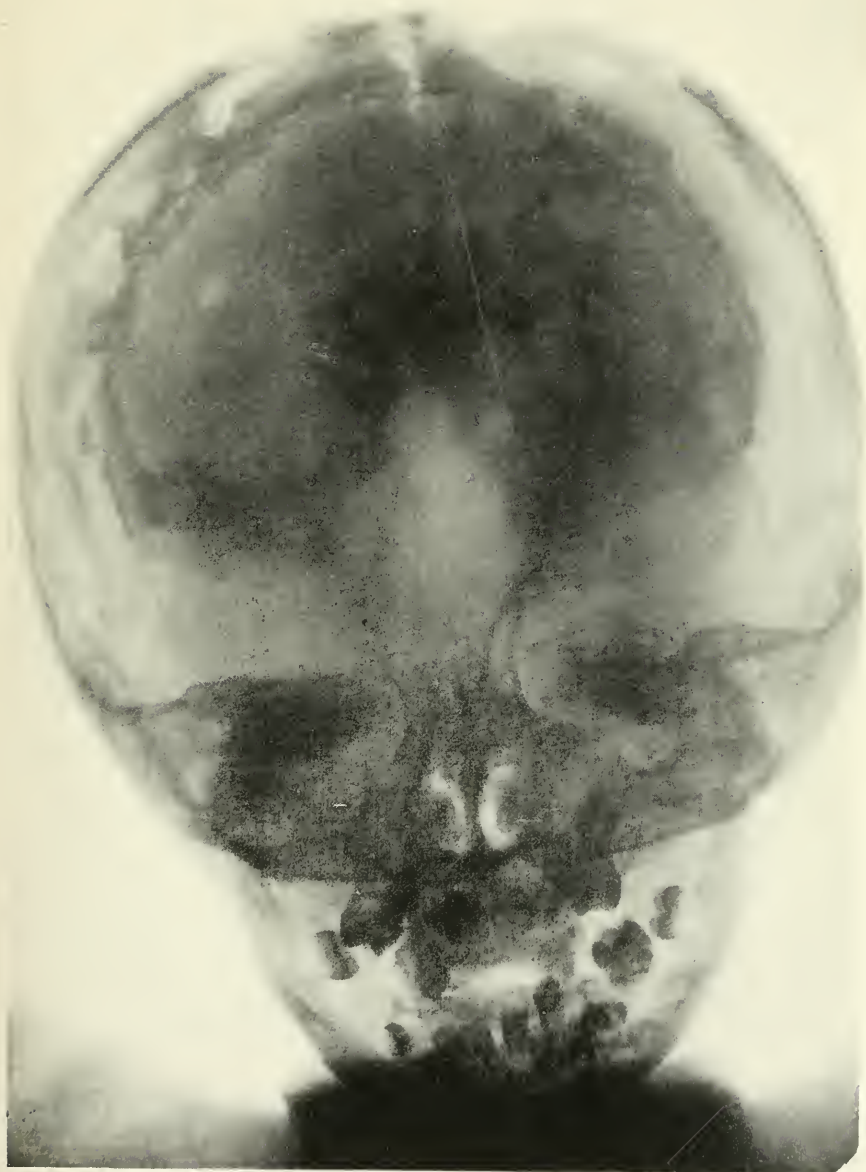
ROENTGENOGRAM OF SKULL.
